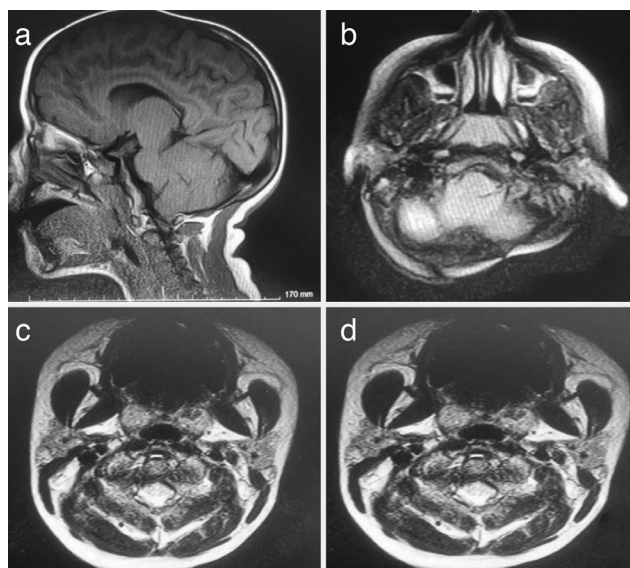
(a,b,c,d) Pretreatment magnetic resonance imaging revealing a mass lesion at the left posterior fossa of cranium
